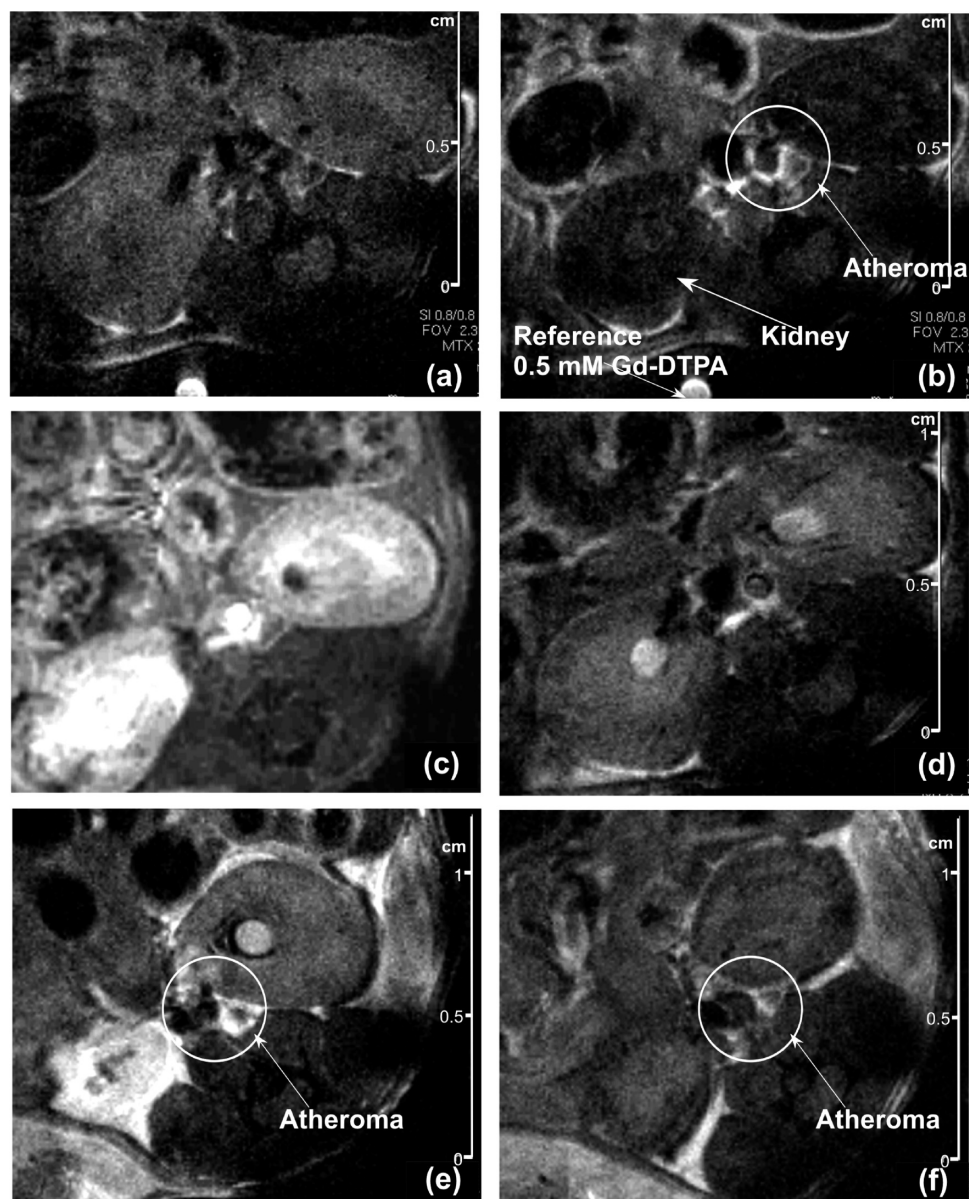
MRI RARE images (spatial resolution = $90 \mu\text{m}$) are shown in precontrast (a) and ~ 30 min post Gd-DTPA-g-R826 (b). They are compared to a TOF image (spatial resolution = $156 \times 156 \times 625 \mu\text{m}$) (c) and to an image obtained post Gd-DTPA (d). The comparison between Gd-DTPA-g-R826 (e) and Gd-DTPA-g-R826.Sc (f) is shown 60 min postcontrast. Images compared in (a)–(d) and those in (e) and (f) are located at the same level of abdominal aorta.
